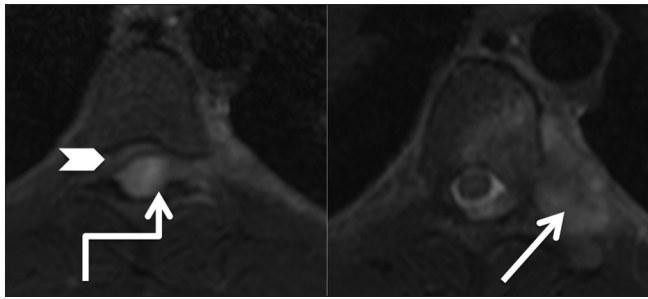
Infective: Tuberculosis: Axial T2-weighted images of thoracic spine at T7-8 level showing posterior epidural abscess (elbow arrow) compressing the cord anteriorly (arrowhead) with edema in cord. Note the involvement of left costotransverse and costovertebral joint (arrow)
